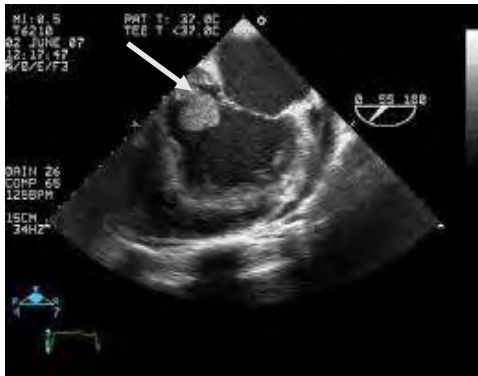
Trans-esophageal ultrasound. Thrombus attached to the intraventricular wall as a result of impaired contractility of the left ventricle (arrow).
